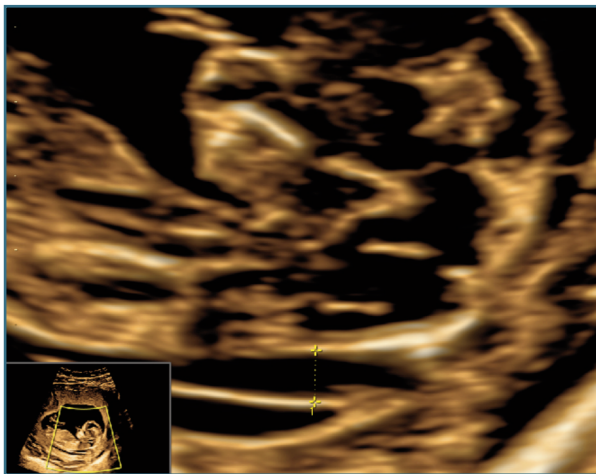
Ultrasonographic evaluation performed at 12 weeks and 4 days showing the midsagittal plan with an enlarged fourth ventricle and a suspected retrognathia.
